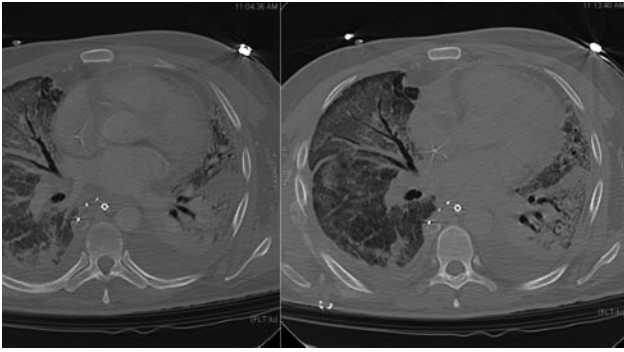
Thin section chest computed tomogram performed with different PEEP values, demonstrating poor recruitment of lung parenchyma in ARDS condition.
